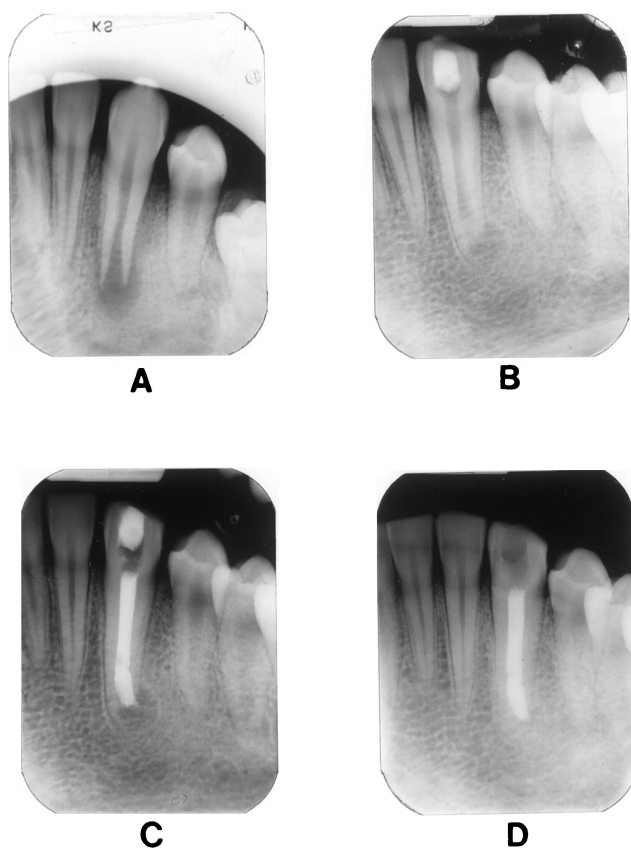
A case of $\text{Ca}(\text{OH})_2$ apexification that formed a mature- looking apex. (A) Radiograph at initial examination. Pulp tests did not elicit any response from tooth #22, and clinically a labial sinus tract was present. A "blunderbuss" apex and periradicular rarefaction are seen. (B) Radiograph 2 yr after the start of treatment. Only one additional $\text{Ca}(\text{OH})_2$ treatment had been performed at the 1-yr visit. (C) Radiograph at obturation 2 yr after the start of treatment. Some extrusion of sealer and gutta-percha is seen. (D) Final follow-up radiograph 2 yr 6 months after canal obturation. A morphologically mature apex has formed that seems to have enclosed the gutta-percha within the canal.
